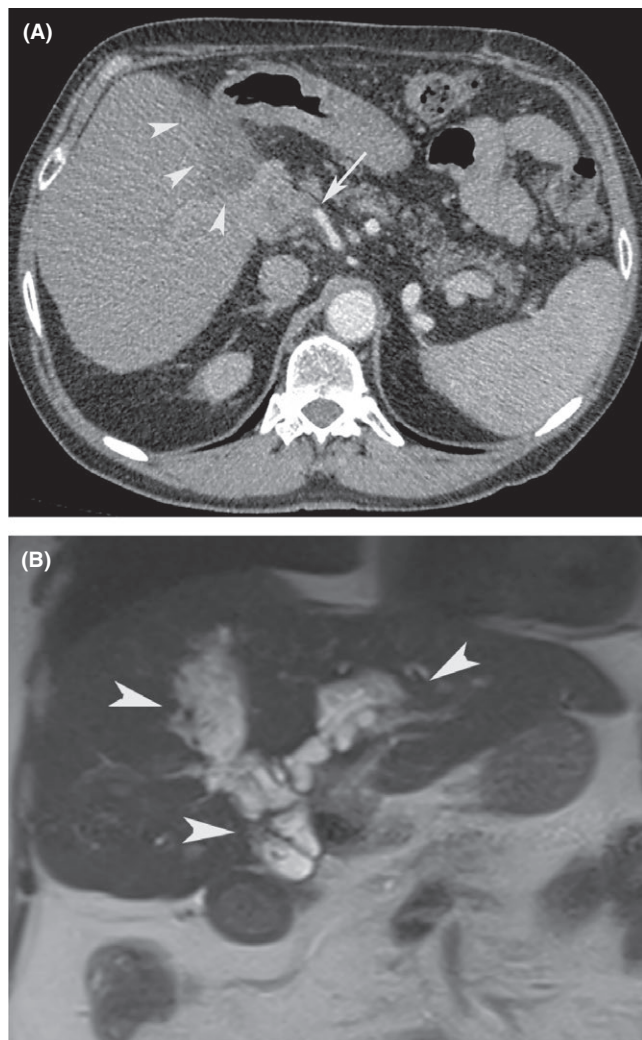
A, CT scan angiography of the abdomen shows hepatic artery thrombosis (arrow), associated with marked dilatation of the central biliary tree (arrowheads), characterizing central biliary necrosis. B, Coronal T2-weighted MR imaging better delineates the extension of the biliary tree dilatation (arrowheads)
